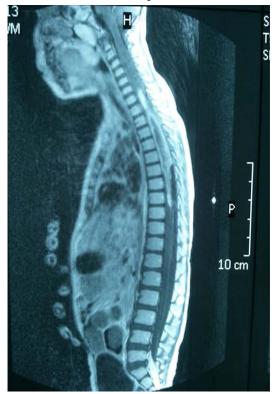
Spinal MRI showing intramedullary with irregular contrast enhancement, between the levels of C7-T8.
